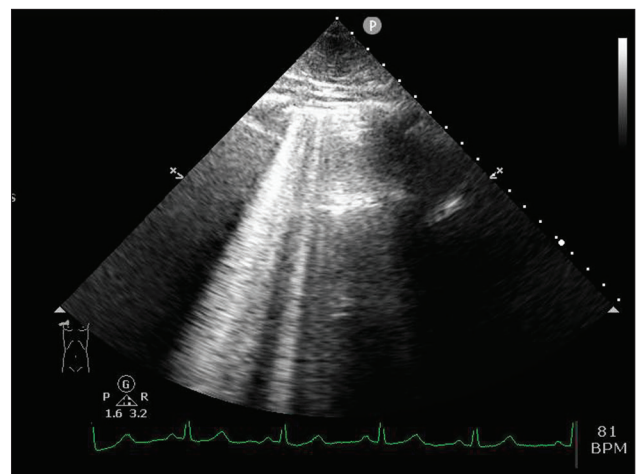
Point-of-care ultrasound image of the lung showing multiple B-lines (comet tail artifacts) consistent with interstitial pulmonary edema
